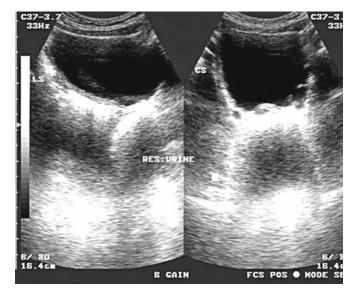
An ultrasound scan shows a thickened bladder wall
